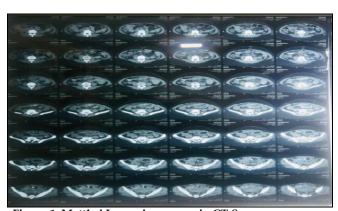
Mottled Lucencies as seen in CT Scan
